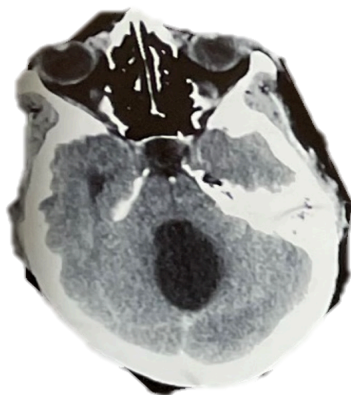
Axial CT-Scan showing a hypodense lesion in the posterior fossa
